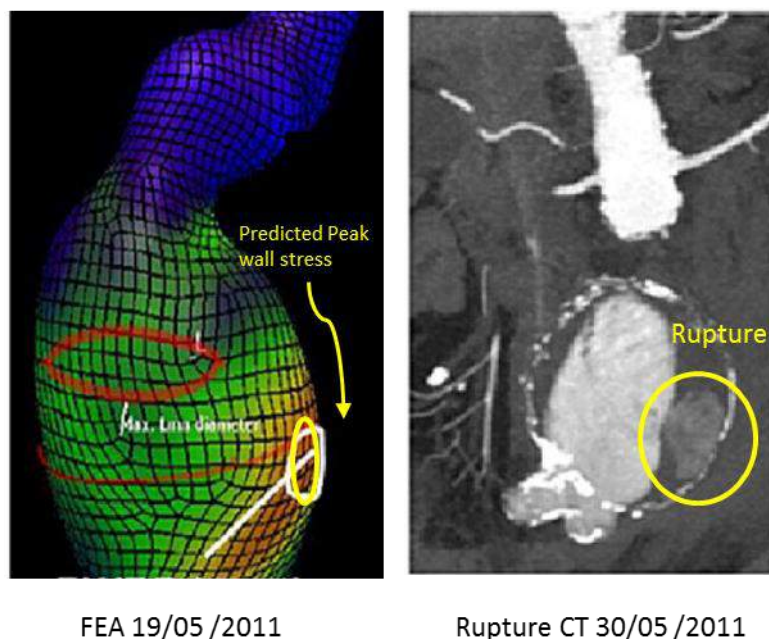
Peak wall stress (FEA/Left) predicted the rupture location (CT image of rupture/Right).[27]
